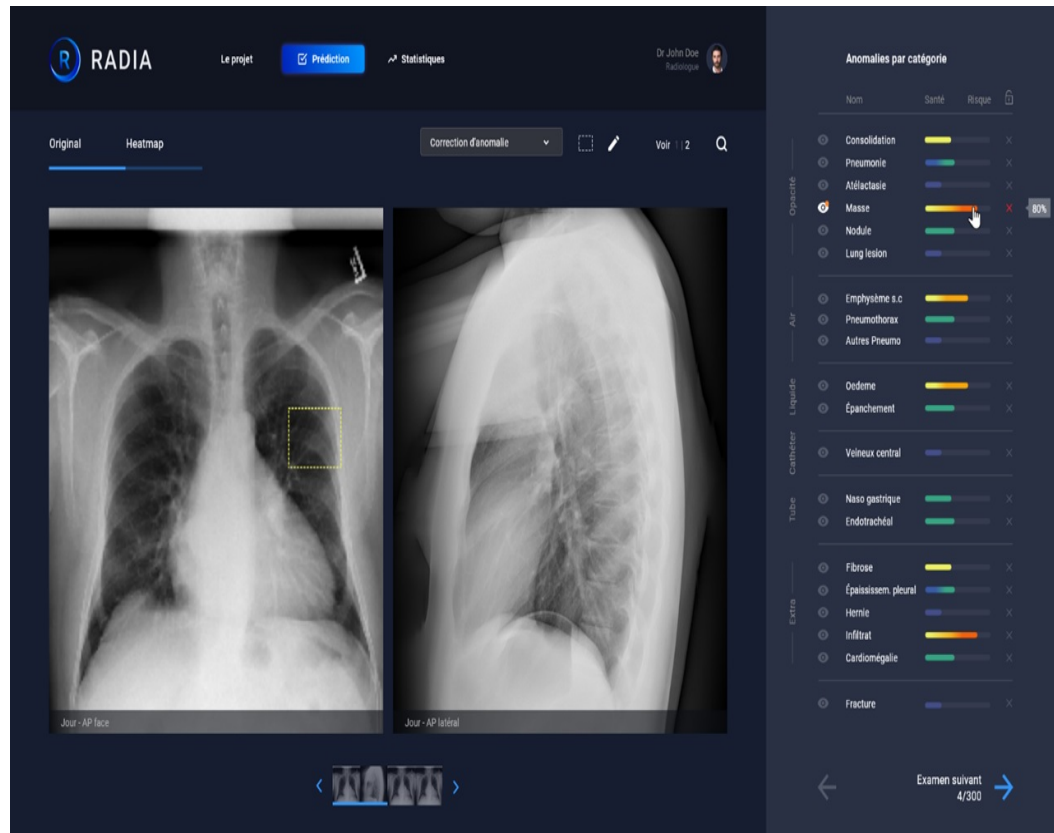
RADIA WebTool interface for anomaly detection in chest X-ray images.
